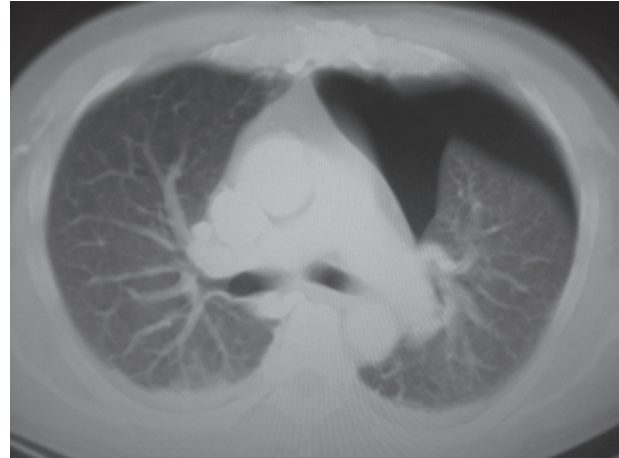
Occult pneumothorax. Large left-sided pneumothorax visible on chest computed tomography (CT) scan, which was not visible on chest x-ray film.
